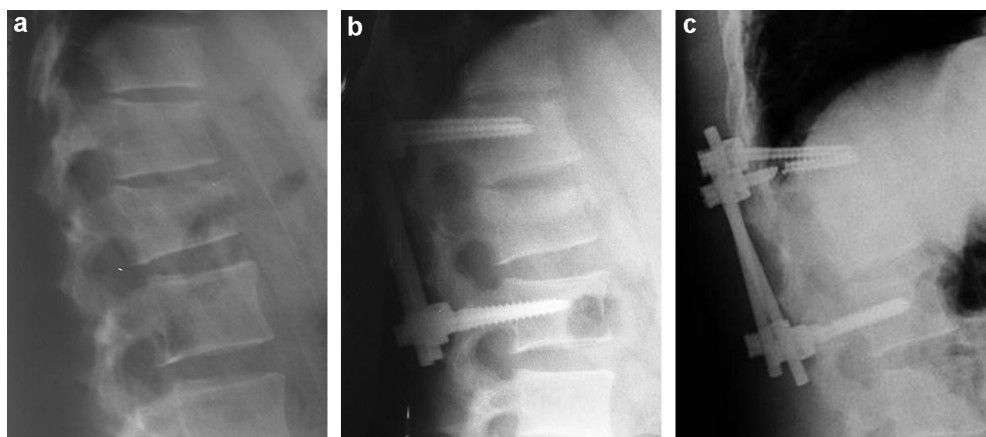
a: preoperative; b: 1 year and c: five years postoperative X-ray showing the failure of percutaneous instrumentation due to the absence of the fusion that leads to cranial and caudal screws breakage.
